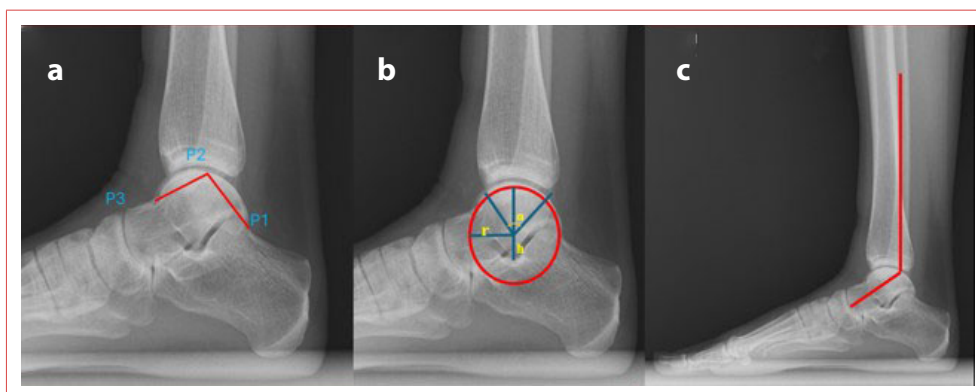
Radiographic measurements of talar morphology on the lateral ankle radiograph. (a) Measurement of the talar convexity angle (TCoA). P1 indicates the posterior tubercle of the talus, P2 the most proximal point of the talar dome, and P3 the deepest point of the transition between the talar body and talar neck; the angle P1–P2–P3 represents the TCoA. (b) Measurement of the talar radius (r), tibiotalar sector angle (α), and talar height (h) using a best-fit circle of the talar dome. (c) Measurement of the fibulotalar angle, defined by the longitudinal axis of the fibula and a tangent to the talar dome.
